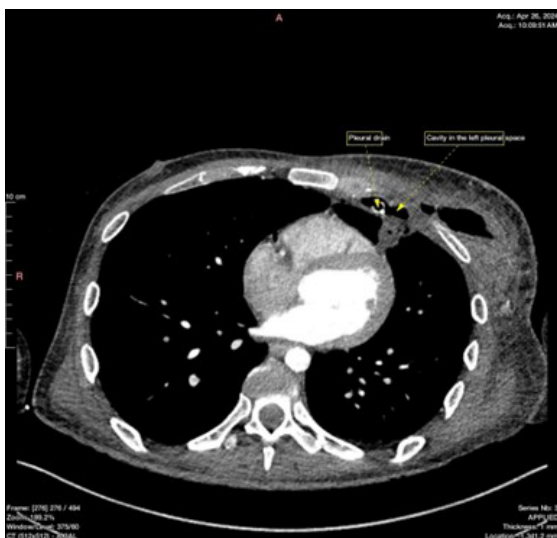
CT Scan Showing the Drain Positioned in the Pleural Space after Passing Through the Fistula.
